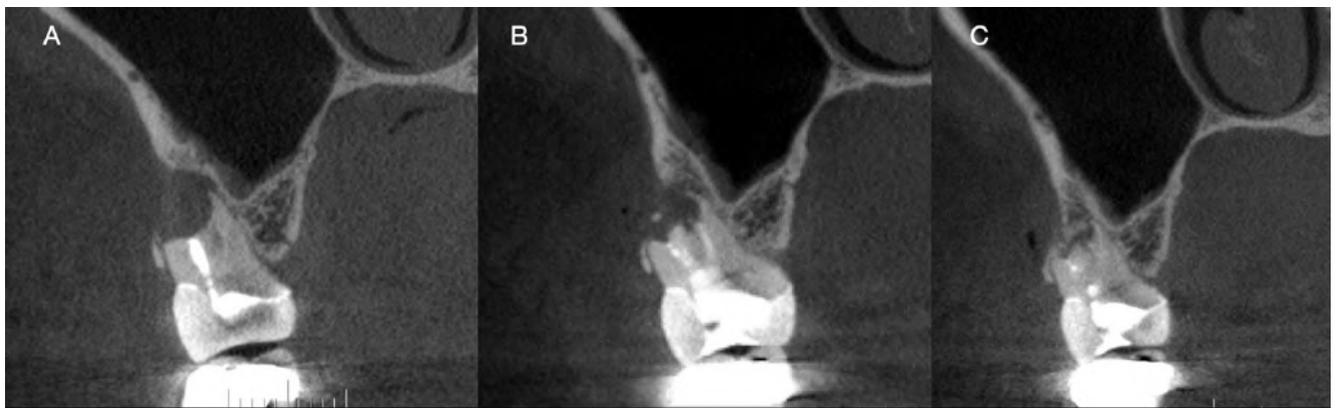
Pos-operative radiograph.
